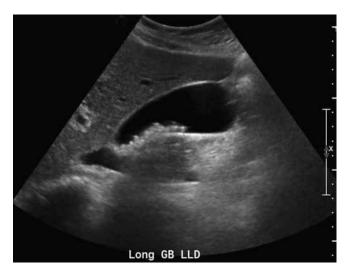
Sonogram shows multiple, hyperechoic gallstones collecting along the inferior wall of an anechoic gallbladder.
